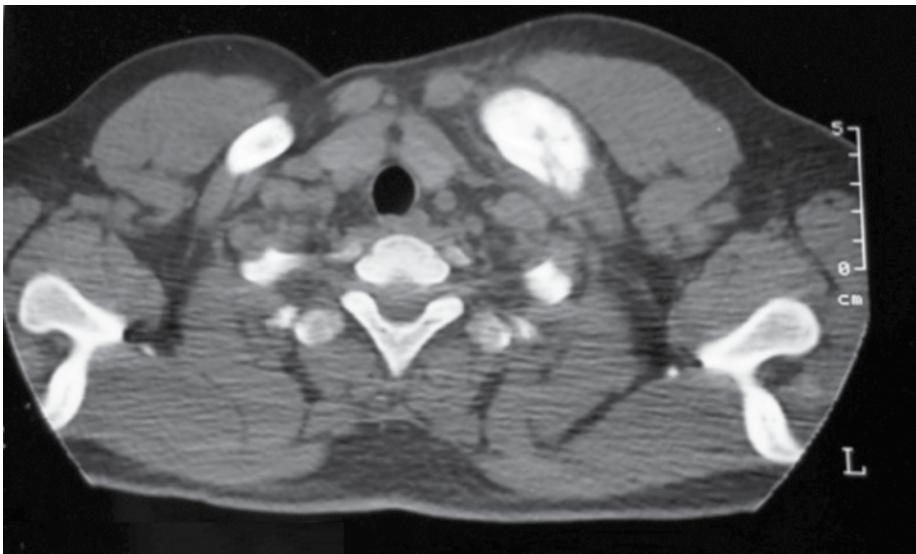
Axial CT scan image of the left clavicle showing sclerosis and increased thickness of cortical bone
